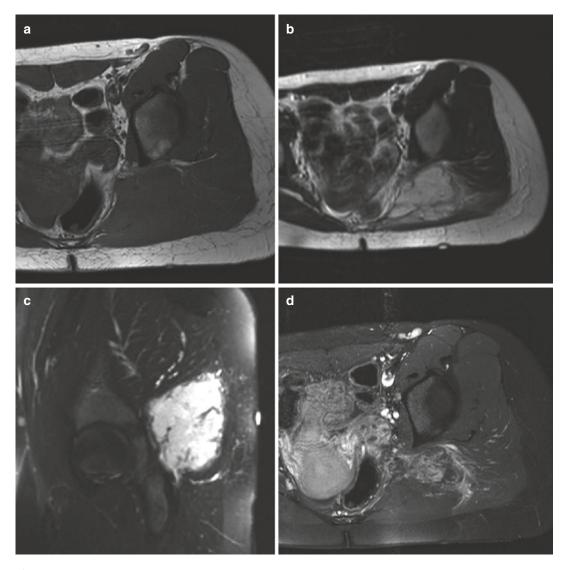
Extrarenal rhabdoid tumor in the left gluteal region of an 18-year-old patient. (a) Axial T1-weighted MR image. (b) Axial T2-weighted MR image. (c) Sagittal T2-weighted MR image with fat suppression. (d) Axial T1-fs-weighted MR image after gadolinium contrast
